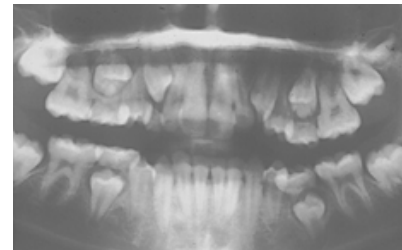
Panoramic x-ray that does not reveal any bony extension.
